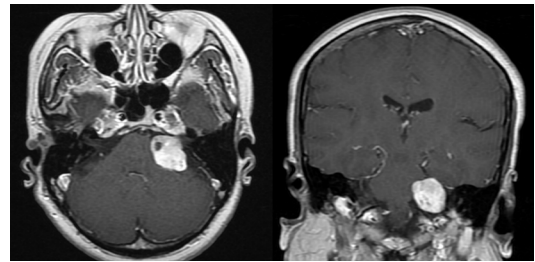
Magnetic resonance imaging (MRI) revealed a 2.1 x 2.9 cm sized acoustic neuroma in the left cerebellopontine angle.
